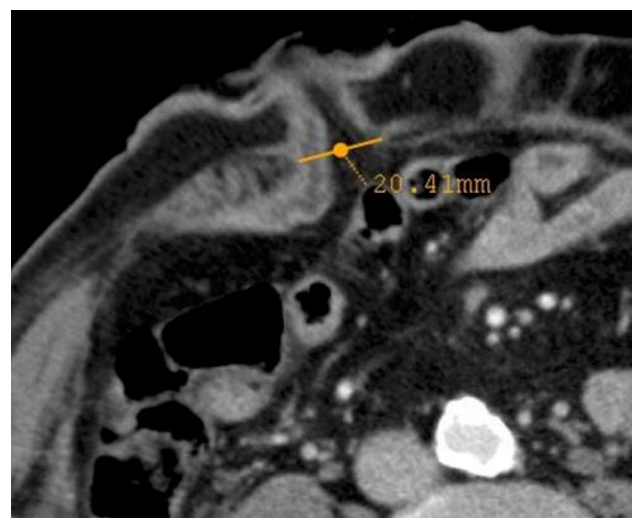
Diameter of the passage through the rectus abdominis muscle for the ileal conduit measured on computed tomography
